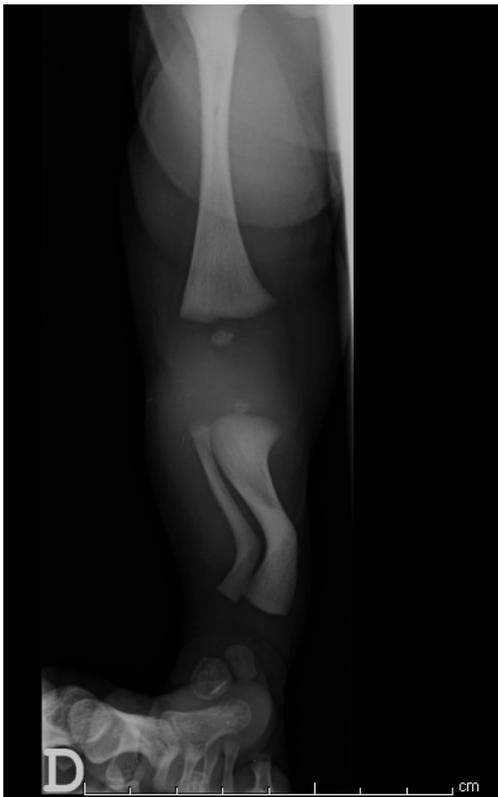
Radiograph of the right leg (first day of life)
